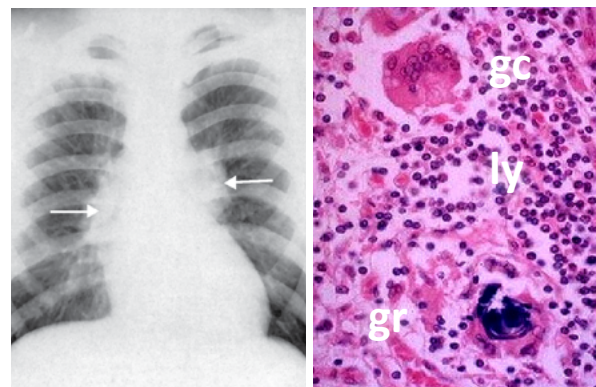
Left: a lung x-ray showing the classic abnormalities of sarcoidosis: bilateral enlargement of the hilus glands (lymph nodes), see arrows; right: typical tissue abnormalities in sarcoidosis such as a granuloma (gr) surrounded by lymphocytes (ly) and a giant cell with multiple nuclei (mr).
